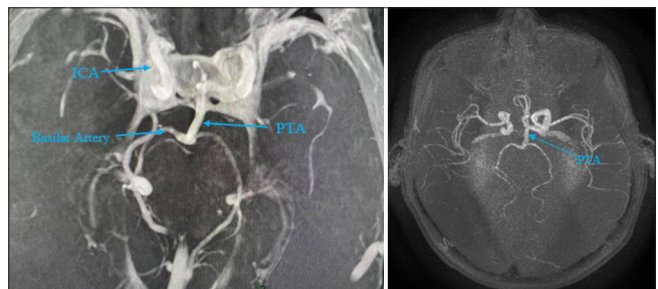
Axial contrasted magnetic resonance imaging showing the persistent trigeminal artery (PTA). The image clearly demonstrates the PTA's path, emerging from the internal carotid artery (ICA) and coursing posteriorly. The contrast enhancement highlights the artery's trajectory and its relationship with adjacent cranial structures, providing essential visual information for assessing the clinical implications of this vascular anomaly.
